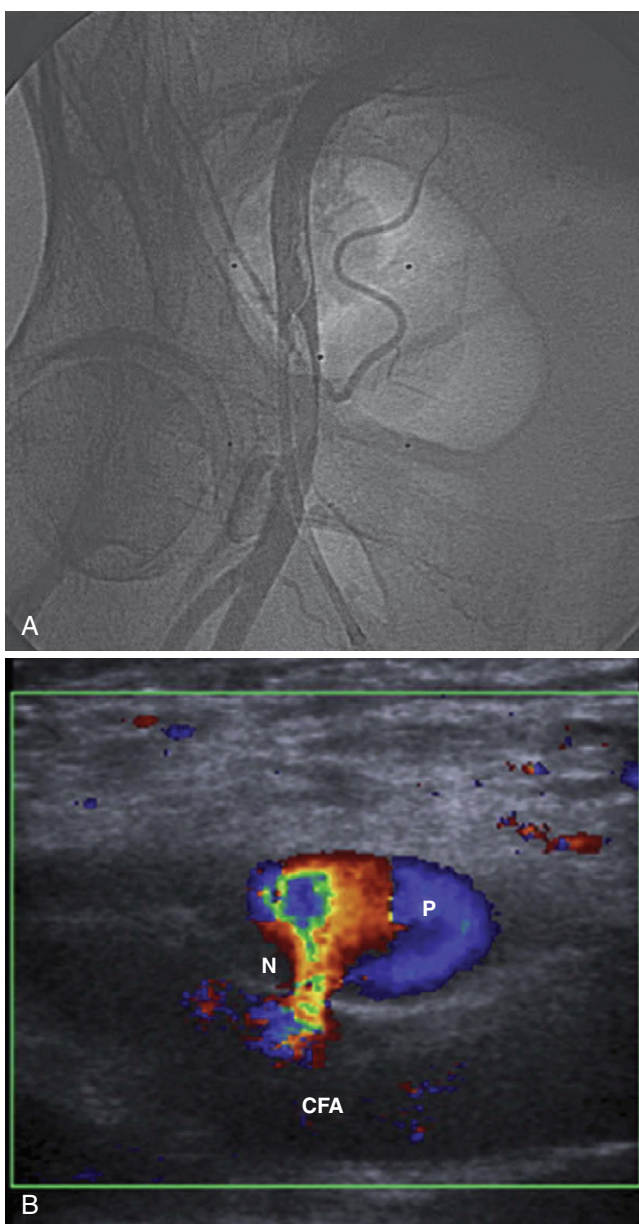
A, Cineangiogram frame of femoral artery dissection. This problem may be associated with limb ischemia or bleeding. It may require surgery but more often can be treated by contralateral access and implantation of iliac stent. B, Ultrasound picture of a pseudoaneurysm (*P*) arising from the common femoral artery (*CFA*). The circular color object is the hematoma which is fed by blood flow from the artery through the characteristic narrow neck (*N*). (From Ahmad F, Turner SA, Torrie P, et al. Iatrogenic femoral artery pseudoaneurysms—a review of current methods of diagnosis and treatment. *Clin Radiol* 2008; 63:1310-1316, Fig. 1.)
